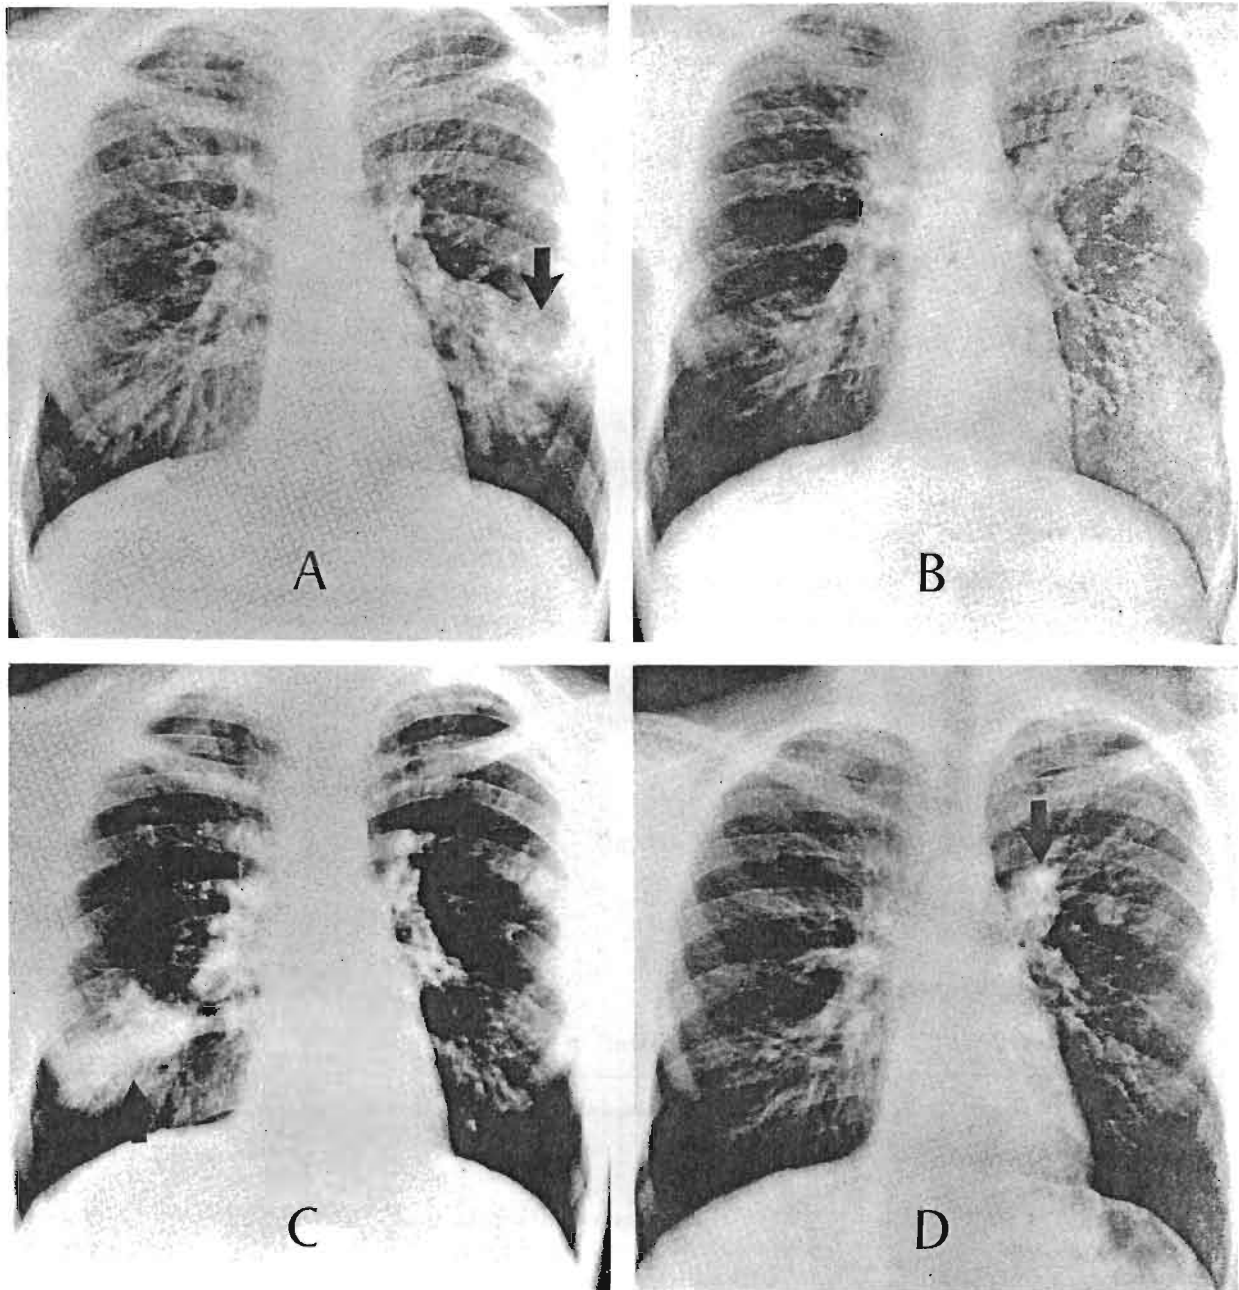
A, B, C, D These four chest radiographs show the characteristic transient or fleeting pulmonary infiltrates in a young man with bronchial asthma and allergic bronchopulmonary aspergillosis.
